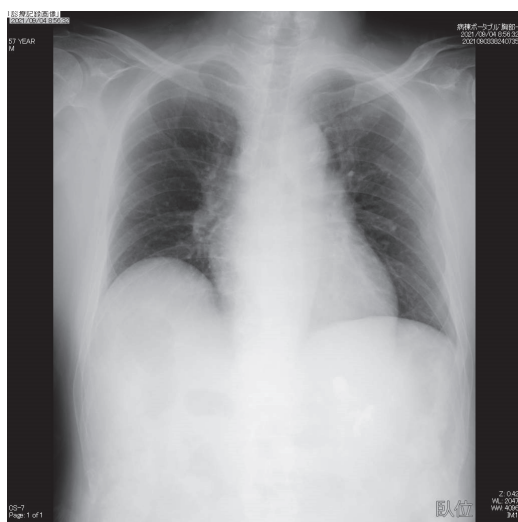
a Chest X-ray on admission, b Chest CT on admission. No pneumonia shadow was observed.
